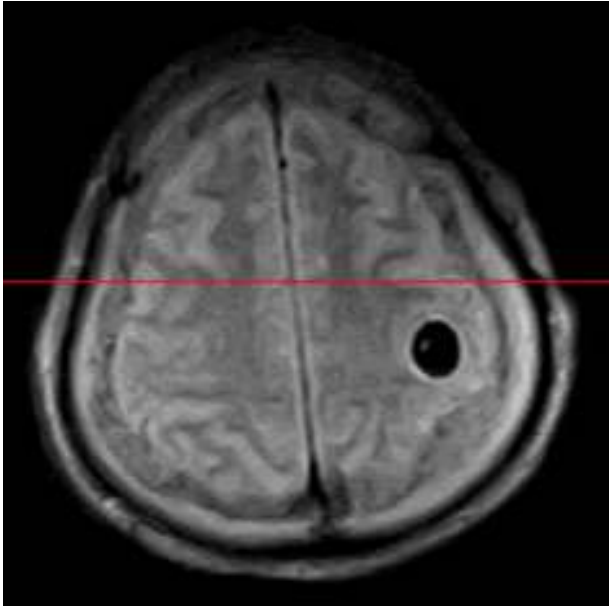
Brain MRI showing a cystic lesion in left parietal lobe without significant mass-effect of surrounding edema.
